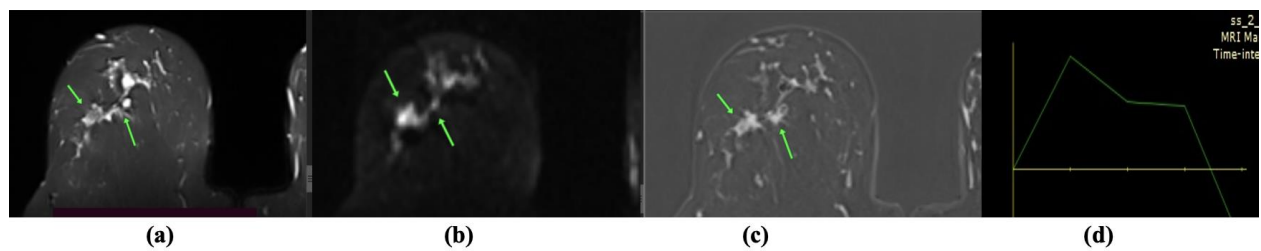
58 years old lady presented with right lump. (a) Axial STIR showed right two upper outer and central masses. (b) DWI showed restriction with ADC value of $(0.8 \times 10^{-3} \text{mm}^2/\text{sec})$. (c) Axial DCE images show two irregular masses with enhancing rim at masses at 11 o'clock and 12 o'clock axis (green arrows). (d) TIC showed type III curve in both lesions. Patient did mastectomy and revealed: multifocal TNBC, IDC NOS grade II.
